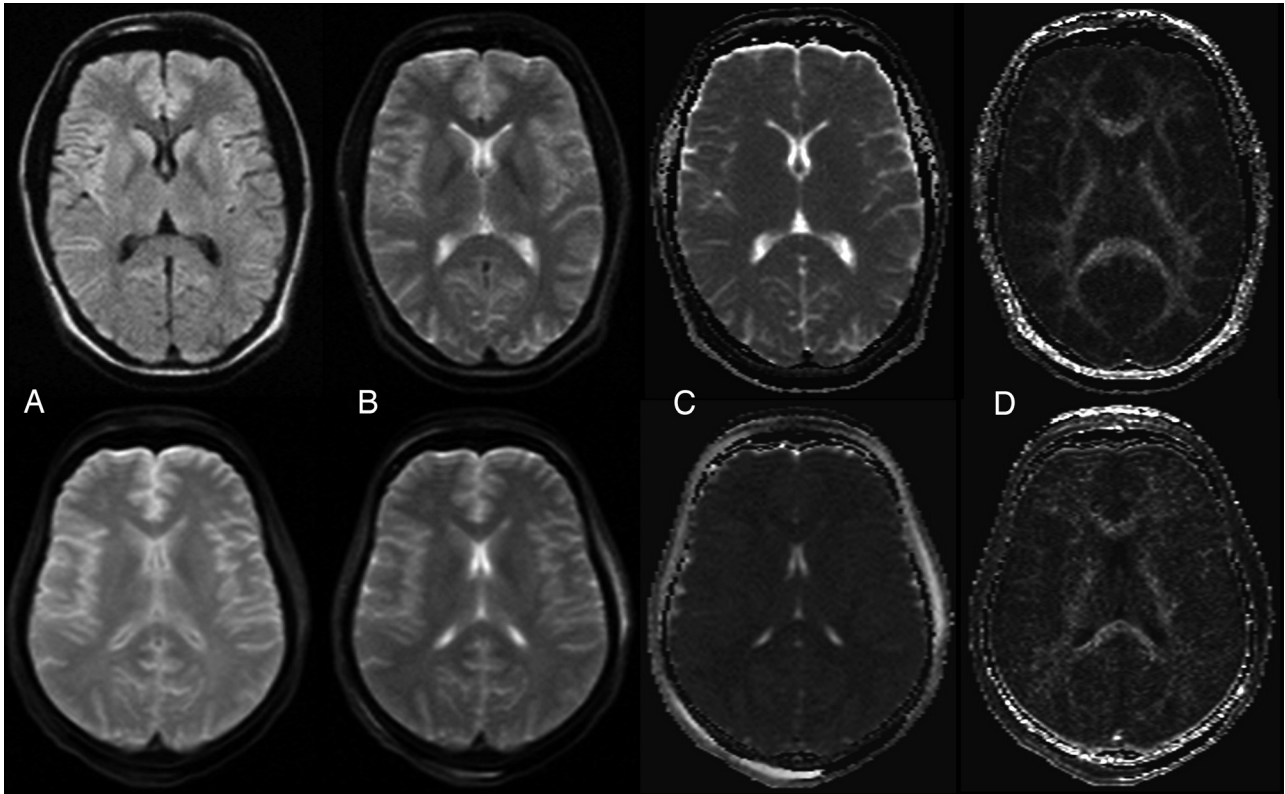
Example of a DWI image, b_0 image, ADC map, and FA map of a healthy living volunteer (woman, 31 years) (top row) and a deceased subject (woman; age, 45 years; PMI, 73 hours; body temperature at acquisition, 12°C) (bottom row). A, DWI ($b = 1000 \text{ s/mm}^2$). B, Trace-weighted image with b -value = 5 s/mm^2 . C, ADC map. D) FA map.
